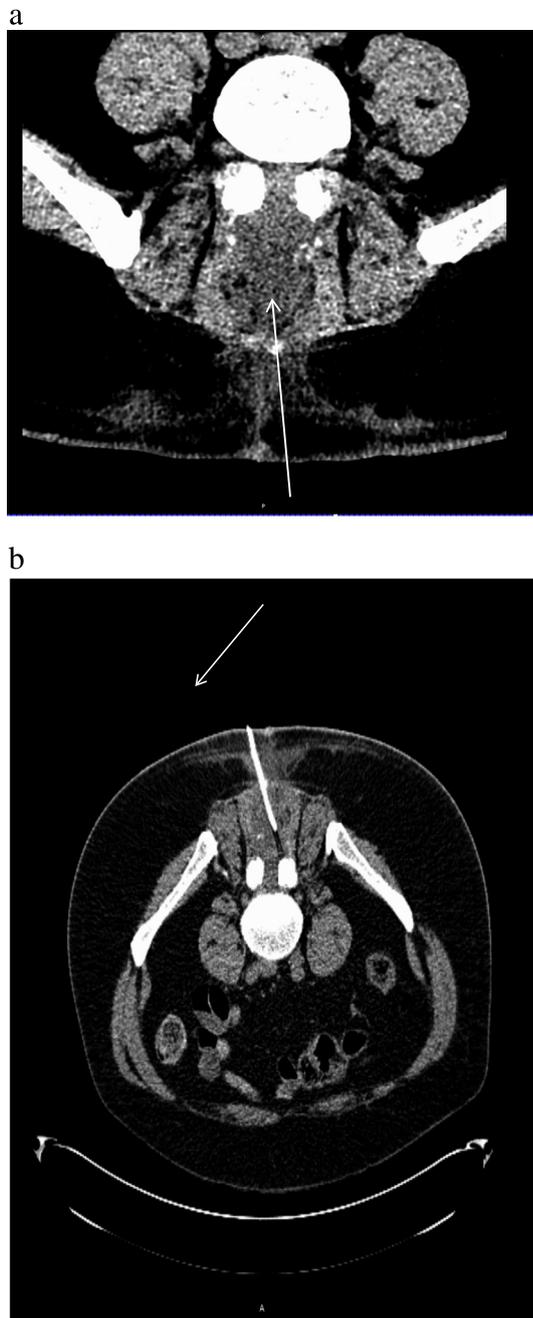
A: Axial CT image. Arrow shows fluid filled space.
